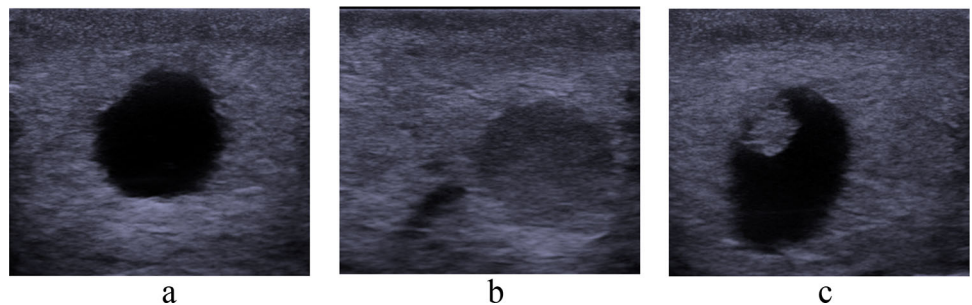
Ultrasound images of cystic (a), solid (b), and cystic-solid (c) models of a thyroid gland nodule were captured with the BK Spectro Ultrasound machine (BK medical, Herlev, Denmark) using 14L3e linear probe operating at central frequency of 9 MHz
